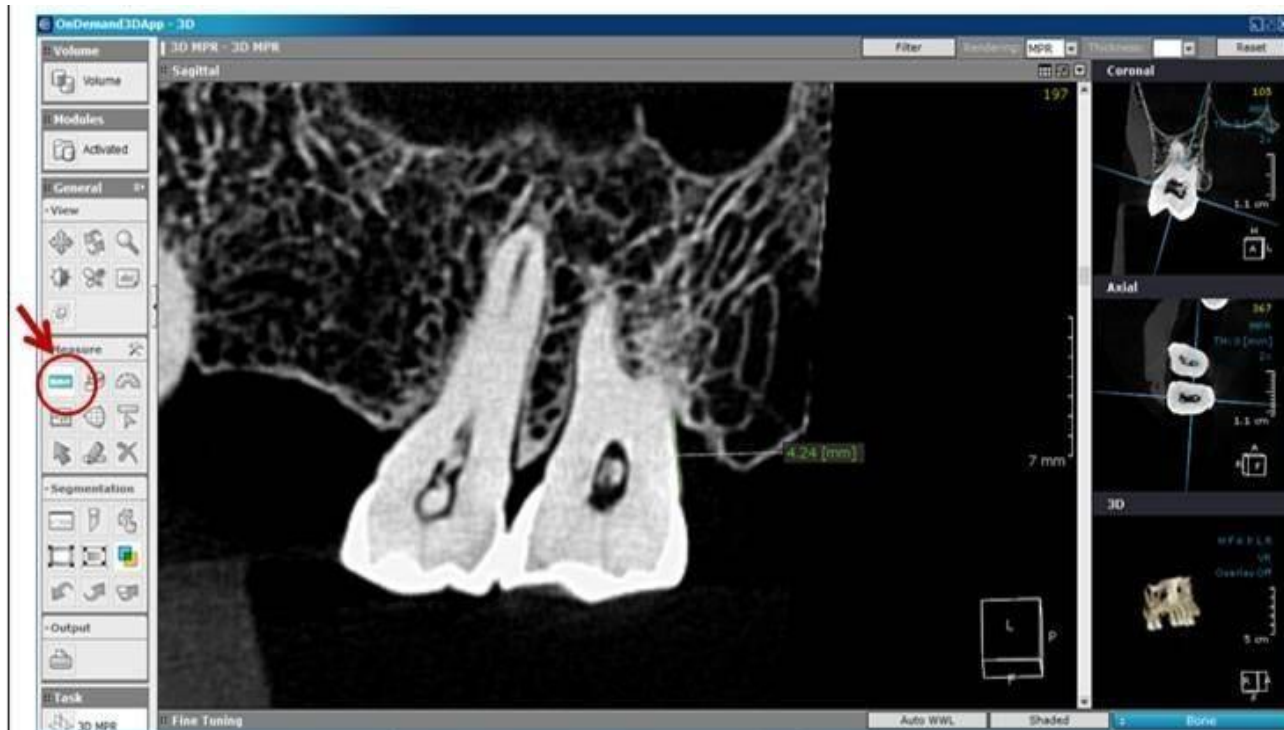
CBCT view showing ruler tool measuring the depth of the angular defect distal to the upper right third molar from the CEJ till the deepest point in the defect on the sagittal cut after the adaptation of the axial plane to be aligned with the level of CEJ and the coronal plane to be aligned with the long axis of the tooth on the other orthogonal planes.
